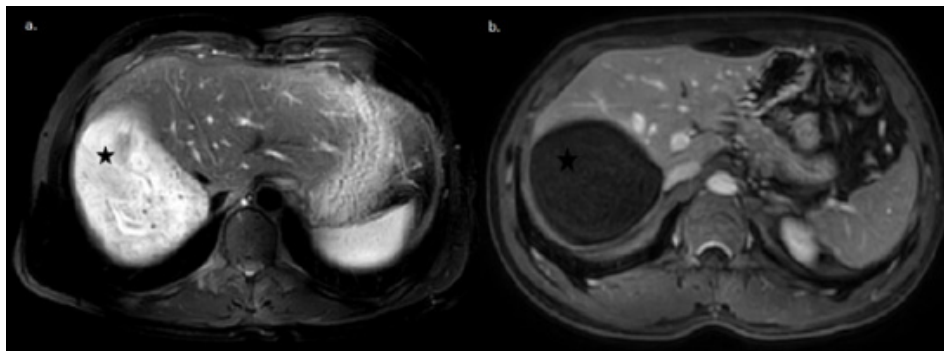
Axial fat suppressed T2W MR image (a) and axial fat suppressed, contrast enhanced T1W MR image (b) show heterogeneous high intensity signal in T2 sequence (a) of the lesion (asterisk) and after intravenous paramagnetic contrast agent administration, there is not contrast enhancement (b) suggesting cystic lesion (asterisk).
